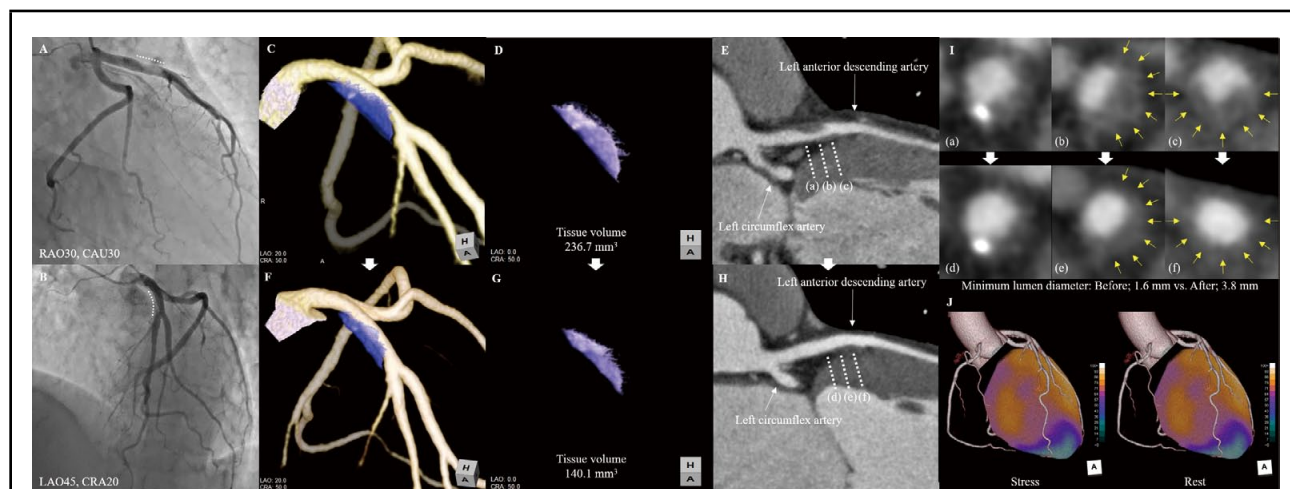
(A,B) Coronary angiograms show haziness suggestive of a large thrombus. Comparison of coronary computed tomography angiography (CCTA) before (C–E) and after (F–H) fibrinolysis, and a cross-sectional image of the culprit lesion (I). (J) Fusion images of stress myocardial scintigraphy and CCTA visualize apex myocardial damage.
